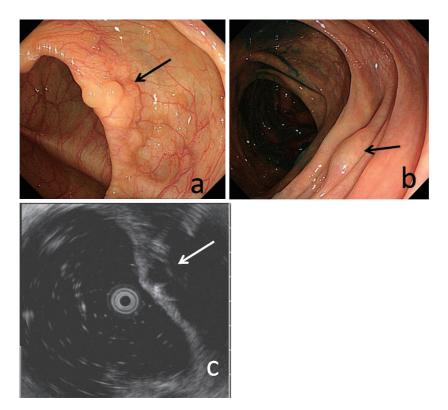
Colonoscopy findings showed multiple submucosal tumor-like lesions in the ascending colon (a) and transverse colon (b) (black arrows). The lesions were sessile, soft, smooth surface and measuring 2-5 mm in diameter. (c) Endoscopic ultrasound findings of the lesions in the ascending colon showed the homogenous hypoechoic mass under the muscularis mucosae (white arrow).
